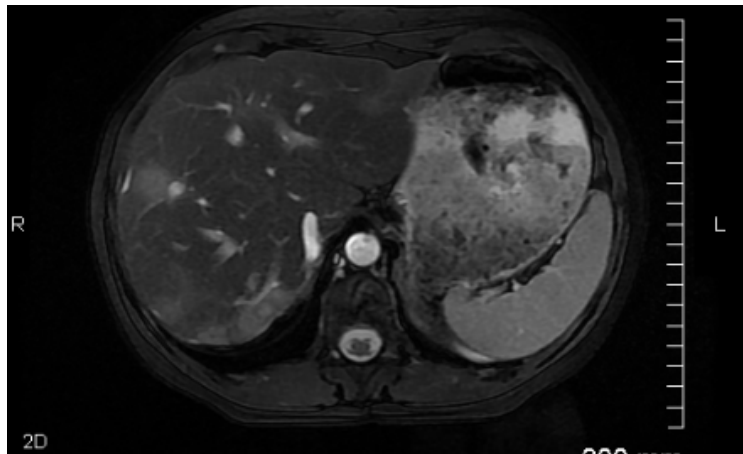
T2 sagittal view of MRI abdomen shows multiple, predominantly peripheral, contrast enhancing nodules in the liver.
